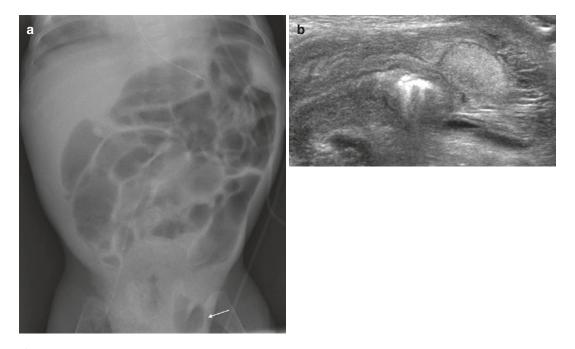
Inguinal hernia. Plain radiograph (a) in a neonate with an inguinal mass demonstrates lucency in the left groin at the periphery of the image, consistent with a
